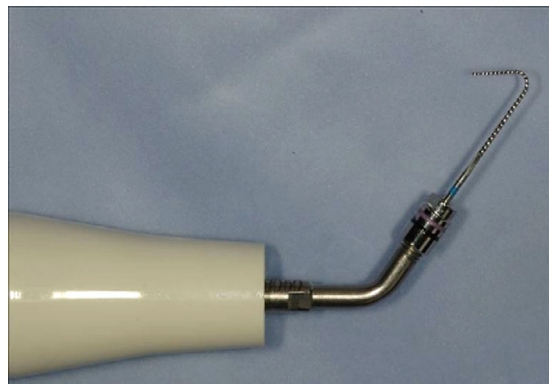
Pre-bent ultrasonic file mounted on an ultrasonic handpiece.
